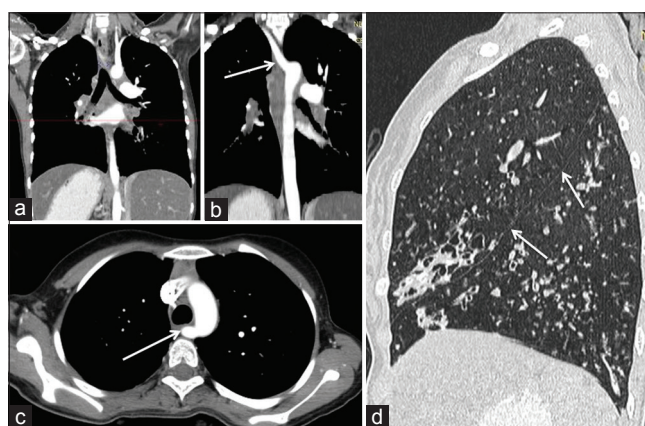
(a-c) Coronal and axial contrast-enhanced computed tomography images of the chest revealed an aberrant origin of the right subclavian artery from the aorta, distal to the left subclavian artery (arrows) and (d) sagittal reformatted image of the right lung reveals only a single major fissure dividing the lung into two lobes suggestive of left isomerism (arrows)
